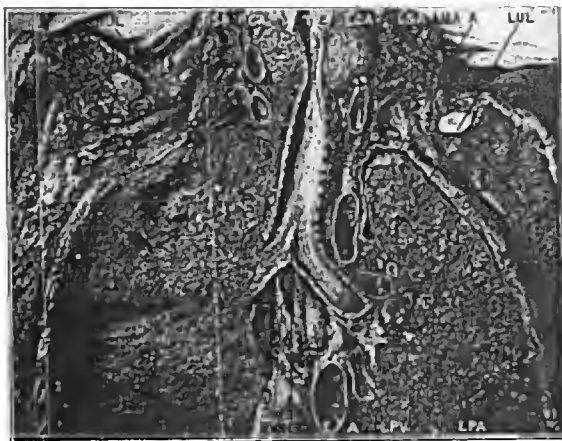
Frontal section of the thorax in the axis of the trachea. This photograph shows (a) the contact of the right upper lobe with the trachea, (b) the mesial position of the left subclavian artery in relation to the left upper lobe, and (c) the essentially anterior position of the right subclavian in relation to the right upper lobe. *RUL*, right upper lobe; *RSA*, right subclavian artery; *RCA*, right common carotid artery; *T*, trachea; *E*, esophagus; *LCA*, left common carotid artery; *LSA*, left subclavian artery; *LMA*, left internal mammary artery; *A*, aorta; *LUL*, left upper lobe; *LPV*, left inferior pulmonary vein; *CT*, carina tracheae; *RVN*, right vagus nerve. (Reproduced from the Archives of Internal Medicine, February, 1909.)
